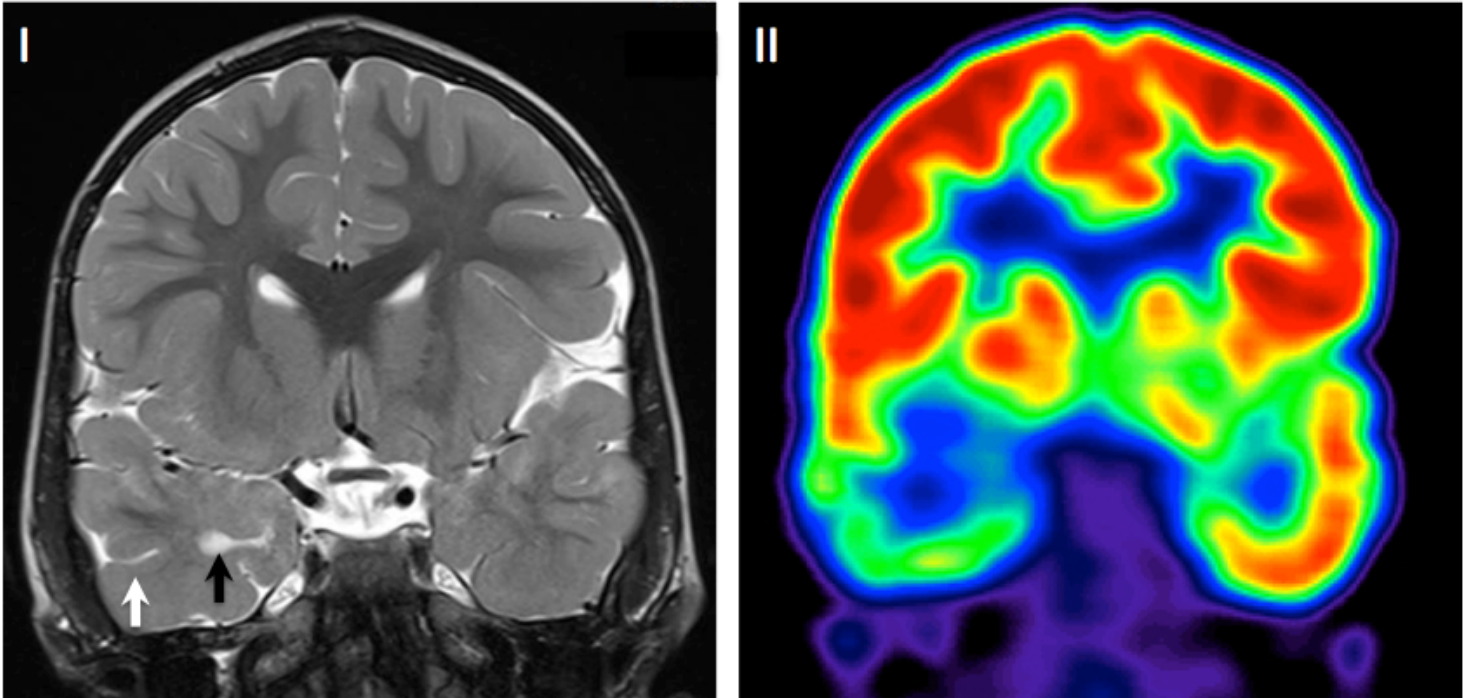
Figure e-2: (A) MRI and FDG-PET of focal cortical dysplasia in individual A:III:2 and (B) MRI of focal cortical dysplasia in individual D:II:1.
